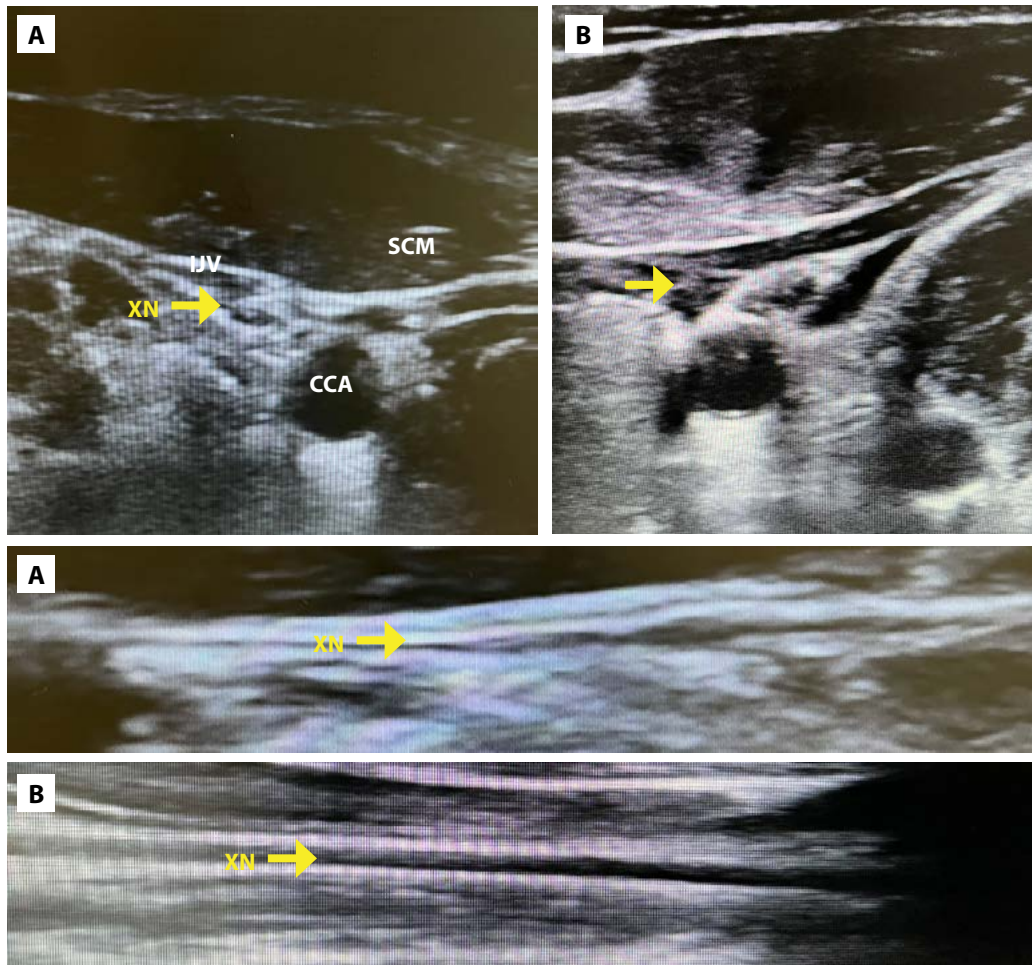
Ultrasound of the XN at the level of the neck in subjects with (A) and without (B) symptoms suggestive of long COVID syndrome
